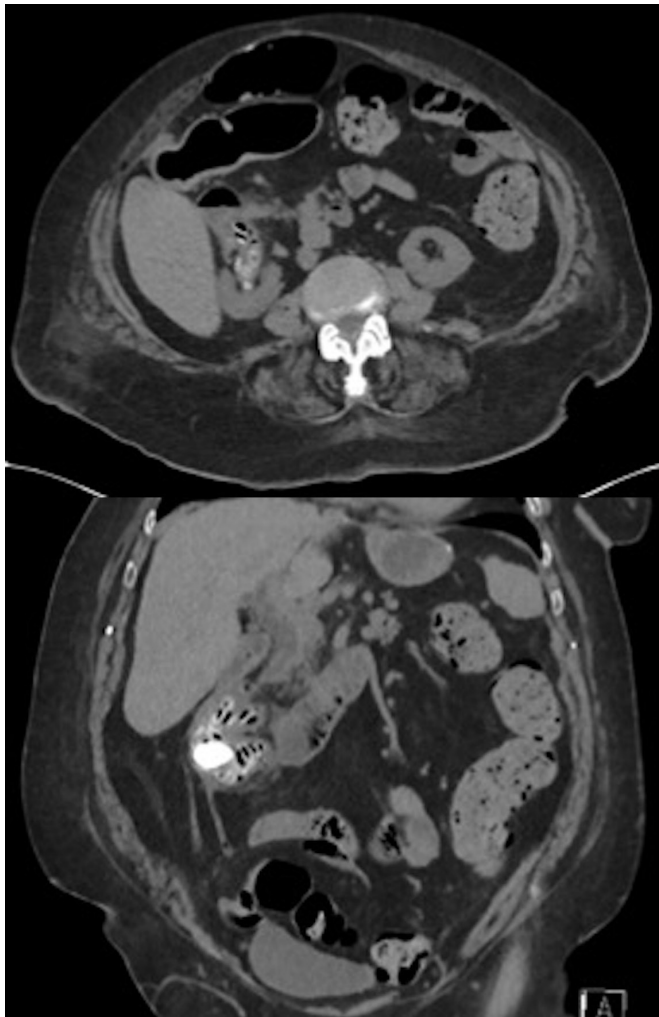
(A) Axial view (above). CT scan of the abdomen and pelvis shows fistulisation between the second portion of the duodenum and the malrotated right renal collecting system. Gas and dense material are present within the dependent portion of the duodenum extending into the renal pelvis and the calyces. (B) Coronal view (below).
